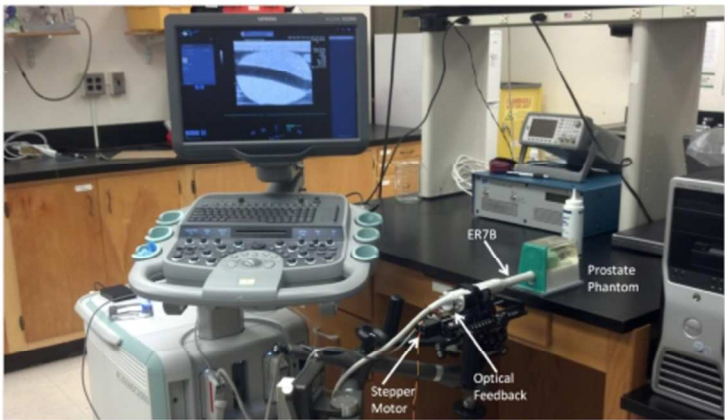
The experimental setup used for ARFI imaging in the operating suite, including the Siemens SC2000 scanner with the ER7B endorectal transducer sitting in a custom cradle of a CIVCO Micro-Touch™ stabilizer with optical feedback controlling a stepper motor to acquire 3D ultrasound imaging data *in vivo*. Custom-written Python code was run on the scanner to trigger B-mode and ARFI imaging acquisition sequences relative to completed rotation increments of $\sim 1^\circ$.
